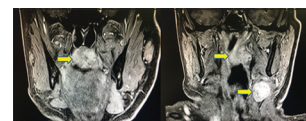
Magnetic resonance T1-weighted imaging with Gadolinium Contrast Media (GADO) contrast coronal view showing heterogeneous soft tissue in the left soft palate and submandibular region
